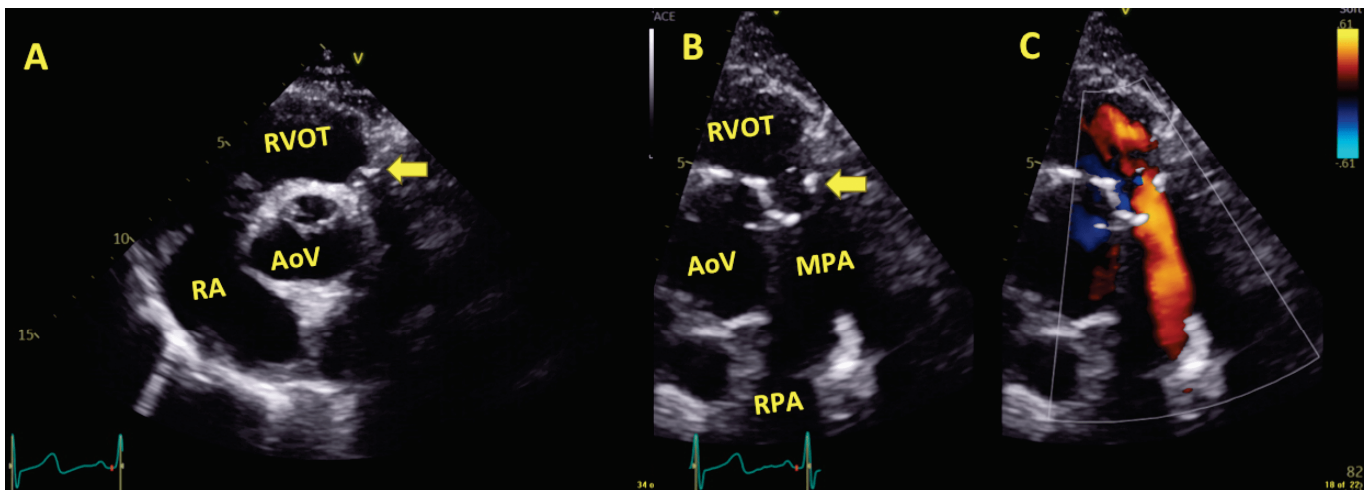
Transthoracic echocardiography Parasternal short axis view; Panel (A): Degenerative homograft cusps (yellow arrow, diastolic phase); Panel (B): Degenerative homograft cusps (yellow arrow, systolic phase); Panel (C): color Doppler showing the regurgitation originating from the right pulmonary artery suggestive of severe regurgitation; Abbreviations: RVOT: Right ventricular outflow track, RA: Right atrium, AoV: Aortic valve, MPA: Main trunk of pulmonary artery, RPA: Right main branch of pulmonary artery.
